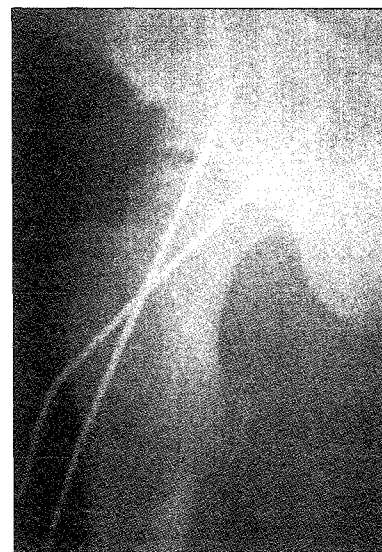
Post-operative check radiograph depicting a non-anatomical fracture reduction and unstable fixation with two smooth Kirschner wires.
